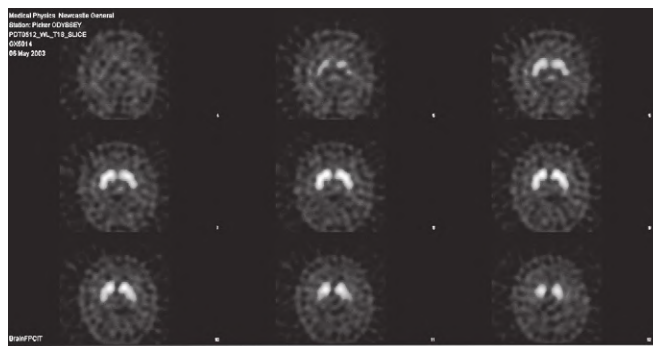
A normal FP-CIT SPECT scan image, showing symmetric tracer uptake in both striata (mirror image commas). In Parkinson's disease, the tail of the comma is lost at an early stage, with the most severe loss being contralateral to the side most affected clinically.
